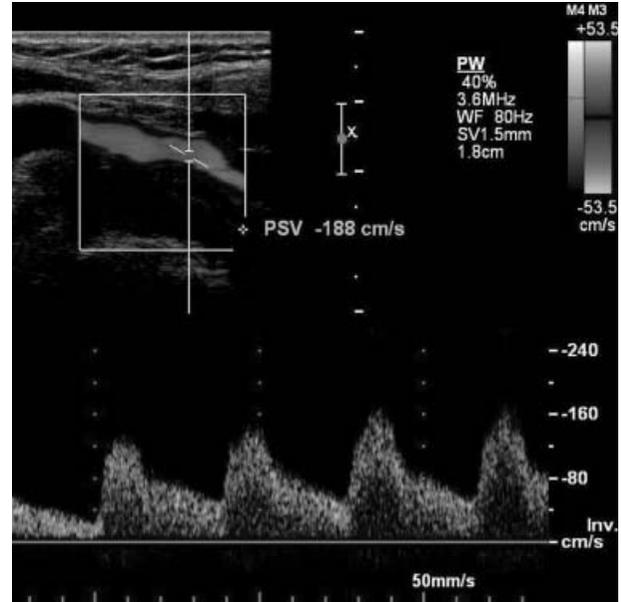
Eco-colour Doppler of right internal carotid artery.
